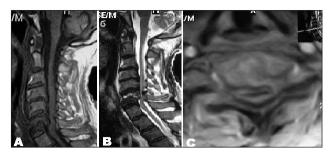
T1-weighted sagittal (*A*), T2 weighted sagittal (*B*), and T1-weighted axial (*C*) MRI images. Vertebral collapse and significant compression of the spinal cord at C6-C7 are present.
